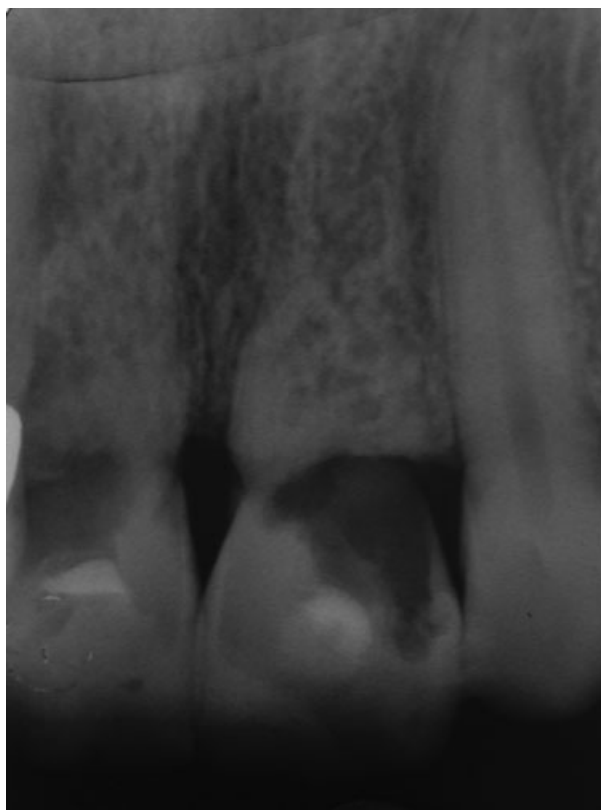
Radiographic examination showing complete root resorption of teeth 11 and 21.
